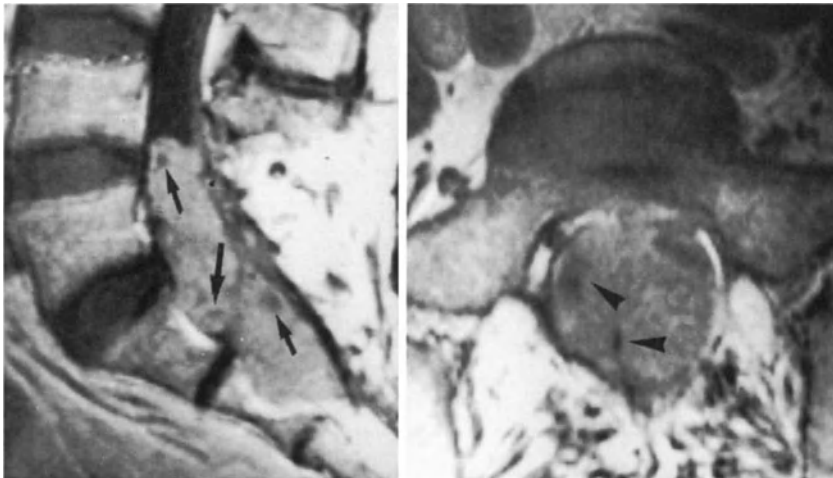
Lumbosacral ependymoma. Sagittal and axial T1-weighted spin-echo MR images after injection of gadolinium. A huge mass entirely fills the thecal sac from L5 to S3. The tumor shows marked enhancement after administration of gadolinium, except for small necrotic areas (arrows). The nerve roots of the cauda equina (arrowheads) appear to be absorbed in the lesion.
